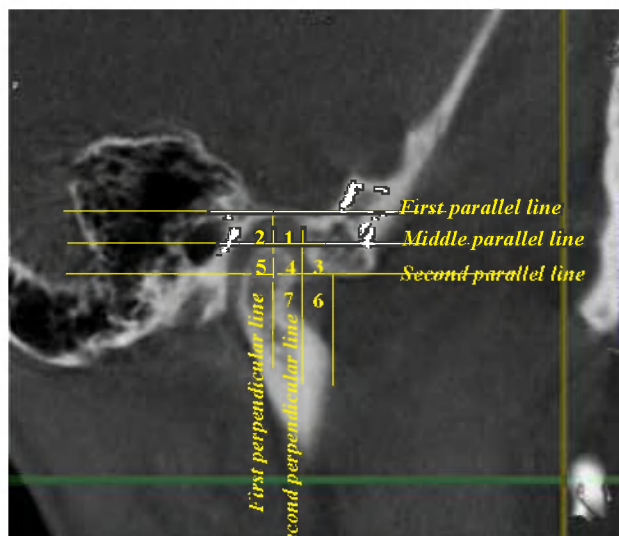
Studying the position of the articular head on the right of patient M. on CT.
